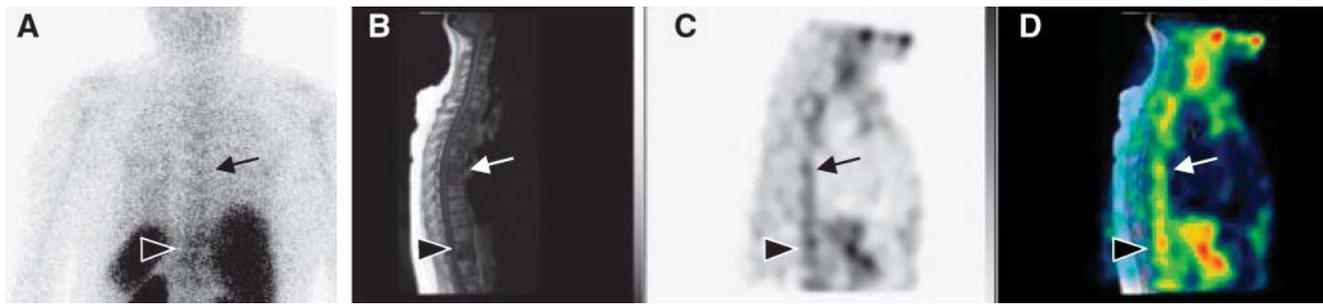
A 59-y-old woman (patient 17) with progression of bone metastasis on tamoxifen underwent ^{99m}Tc -depreotide scintigraphy before she switched to second-line endocrine treatment. (A) Posterior view of planar ^{99m}Tc -depreotide scintigraphy shows relatively uniform tracer uptake in fully invaded spine, mimicking the high physiologic uptake of ^{99m}Tc -depreotide in normal bone marrow. (B) Sagittal MR image depicting extensive tumoral invasion of full spine with total destruction of corpus of thoracic vertebra T11 (arrowhead) and bulky lesion at T5–T6 (arrow). (C and D) Upon fusion with sagittal SPECT images, these lesions coincide with regions of enhanced tracer uptake.
